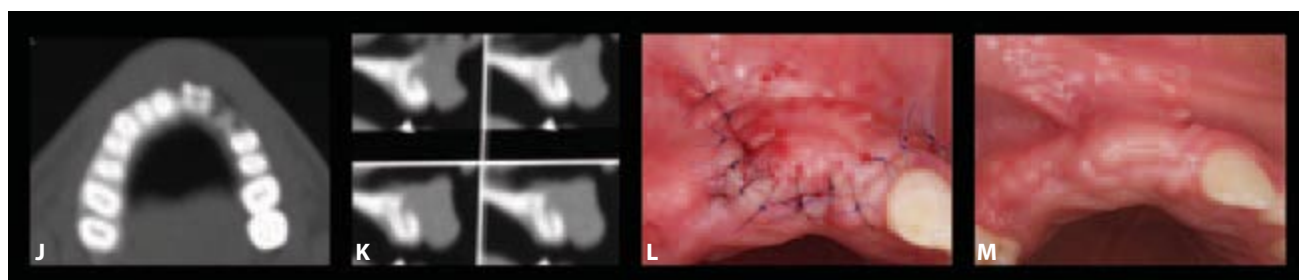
J, K. CT horizontal and axial views showing the osseous topography improvement. L. The area sutured. M. An incisal view of postgrafting tissue profile improvement.
